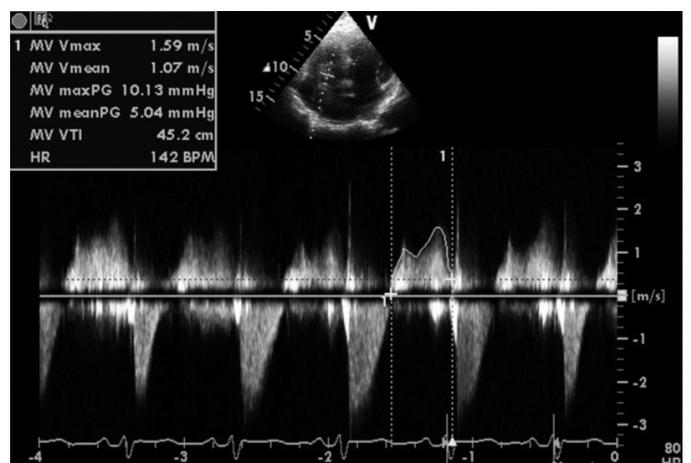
Apical four chamber view demonstrating tricuspid valve occlusion and gradient through valve caused by thrombus by CW Doppler.
